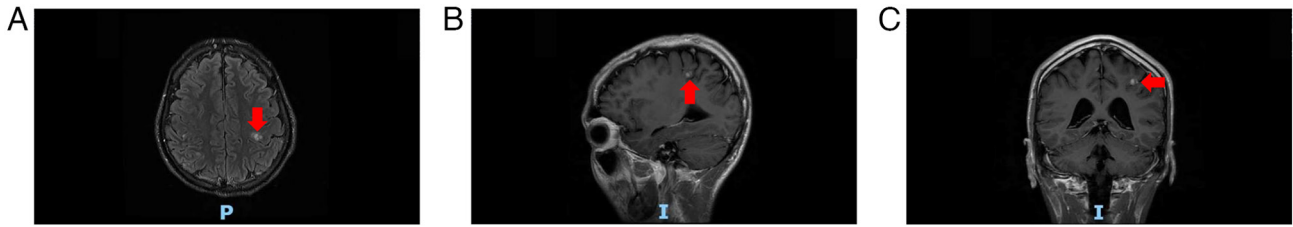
Brain MRI (November 2024). Multiple metastatic foci can be observed, with the largest lesion (red arrows) situated in the left frontal lobe. Images are displayed in (A) axial, (B) sagittal and (C) coronal planes. P, posterior; I, inferior.
